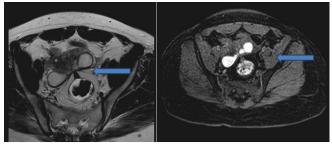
a and b: axial T2 and T1 fat sat sequence MRI: T2 and T1 fat sat hypersignal of the right and left ovaries with fibrous attraction of the 2 ovaries to the uterine fundus (KISSING OVARY), these are endometriotic cysts.
